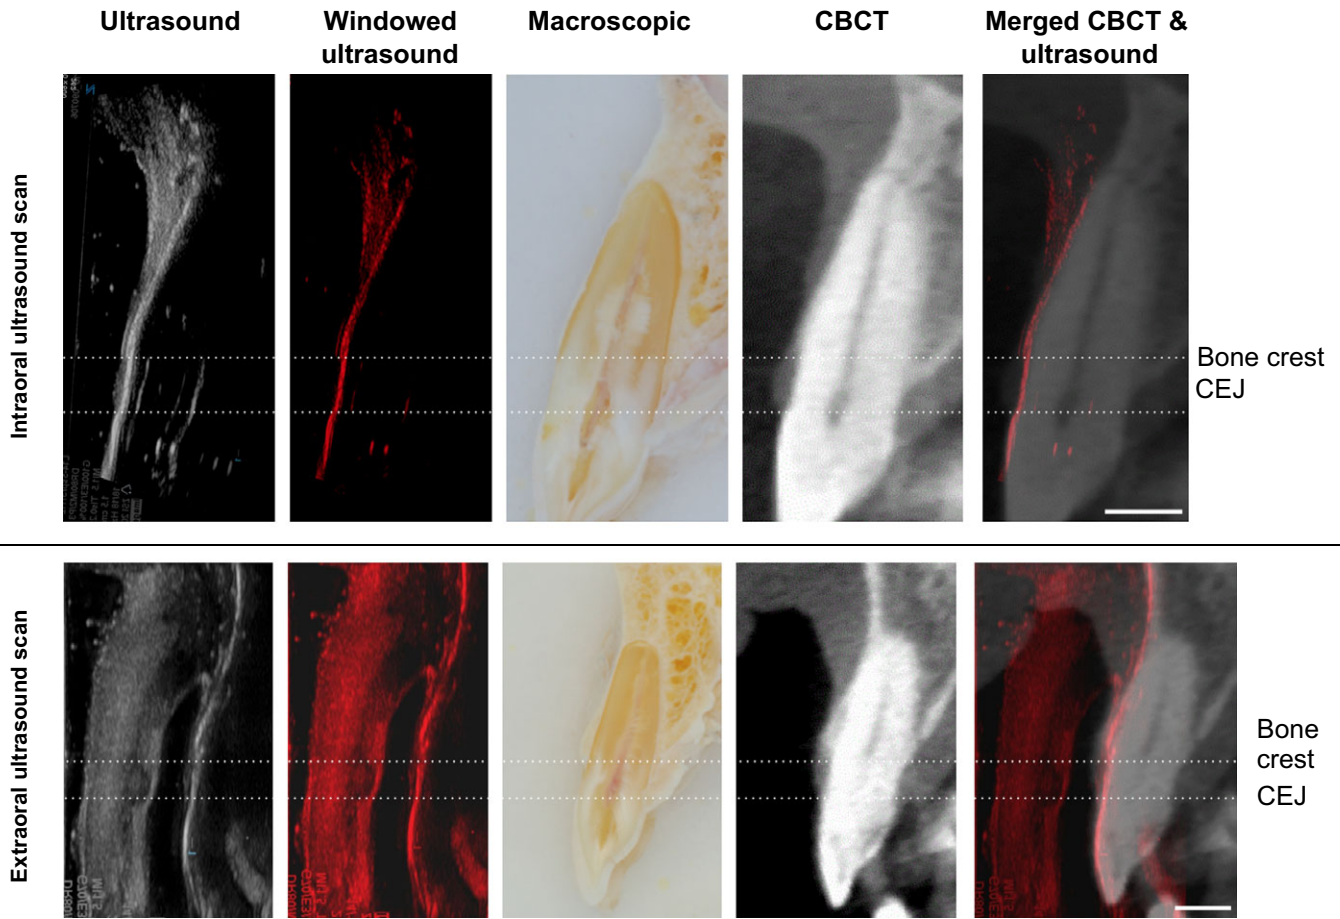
Intraoral and extraoral ultrasound scans of maxillary anterior teeth. The colored and windowed ultrasound image is to highlight hard tissue surfaces that are hyperechoic. A merged image is to show match of the spatial relationship of dental anatomy. On the ultrasound image, the surfaces of enamel, root dentin and alveolar bone are clearly delineated. Additionally, the soft tissue layer, including alveolar mucosa, submucosa and muscle layers, can be seen. On the extraoral ultrasound image, the surfaces of enamel, root dentin and alveolar bone are also clearly delineated. The labial concavity apical to the root apex can be seen with this extraoral scan. Additionally, the soft tissue layer, including the lip, alveolar mucosa, submucosa and muscle layers, can be seen. (CEJ: cementoenamel junction) (Scale bar = 5 mm).
